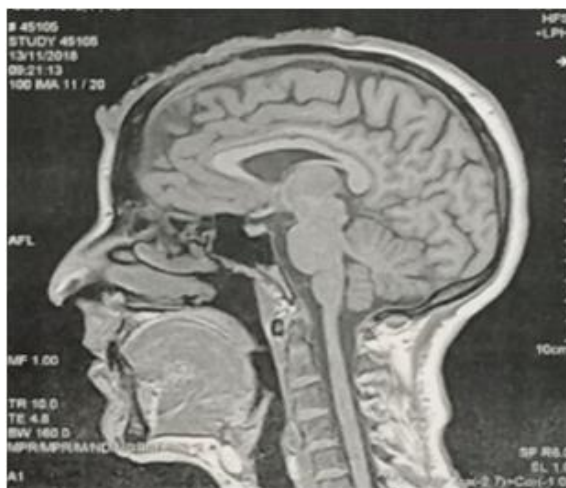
MRI sagittal slice in injected T1 sequence showing the appearance of a CBC of the scalp with frontal bone lysis and infiltration of extra dural space
